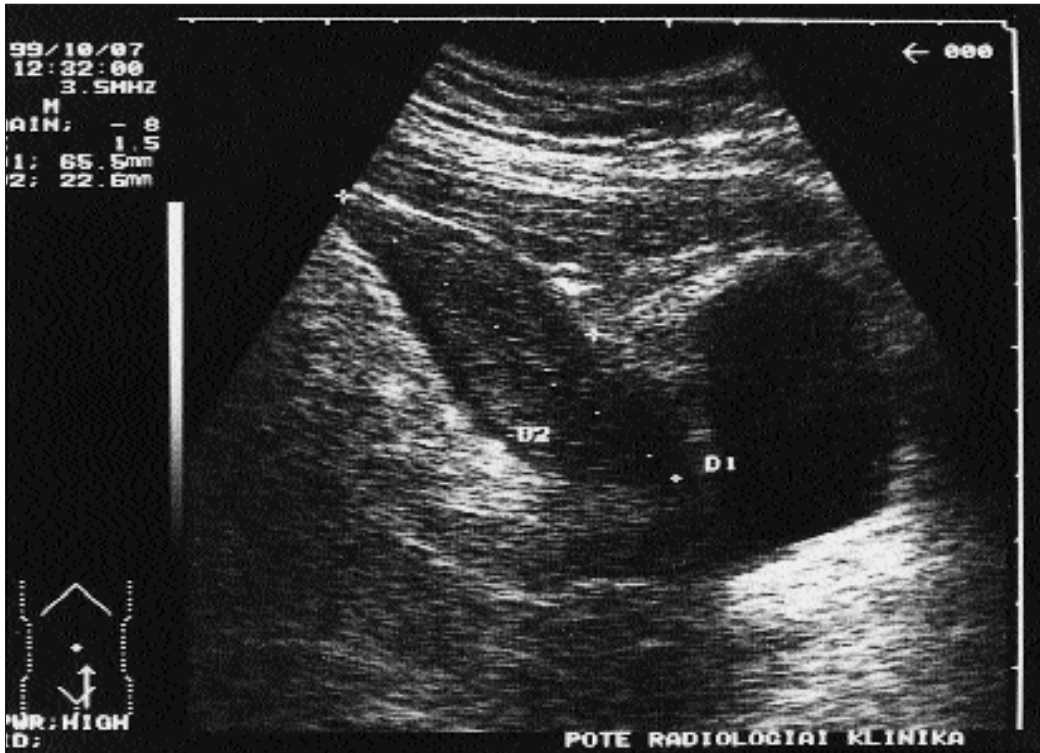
Abdominal ultrasound showing a mass in left lower quadrant in the continuation of sigmoid colon with central reflex representing bowel lumen and symmetrically thickened bowel wall.
